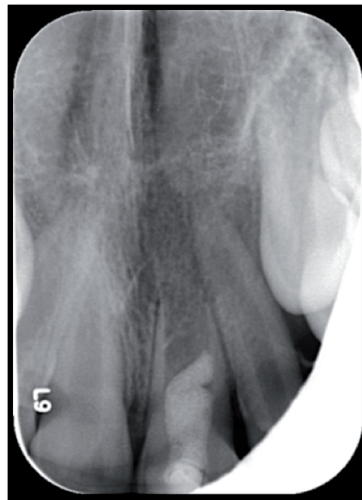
X-ray taken after 3 months.
